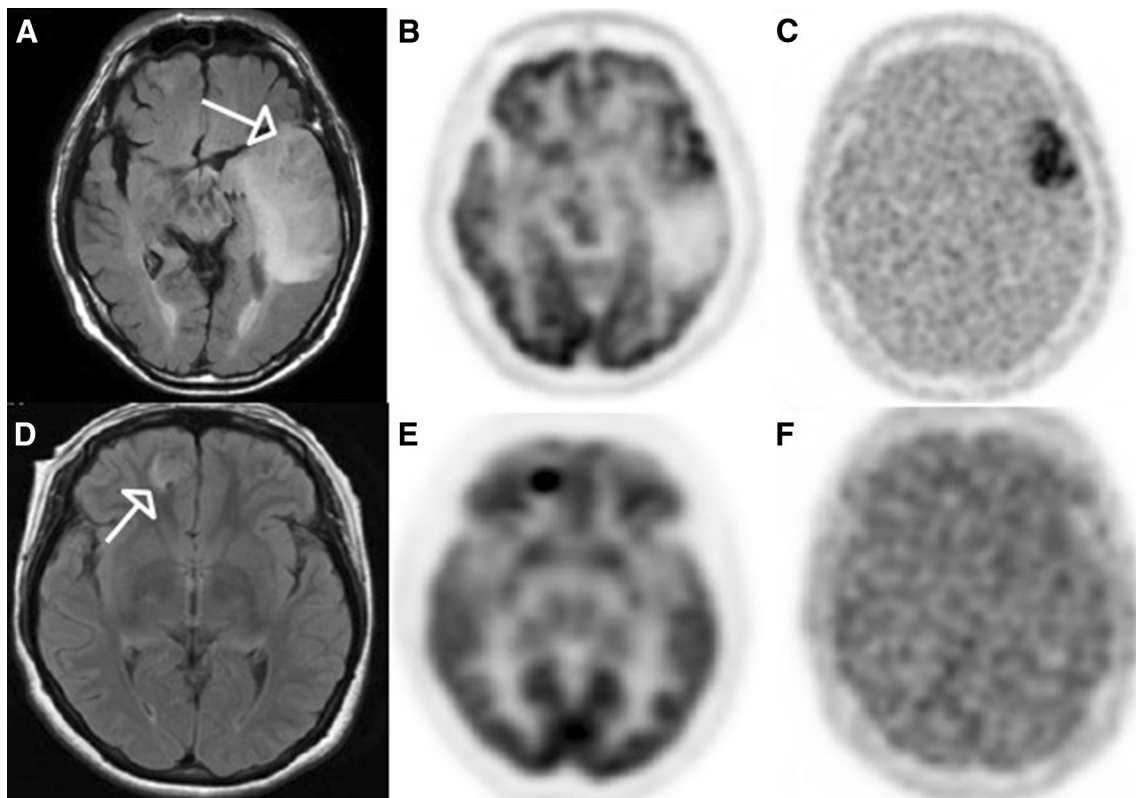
A representative case of glioblastoma (grade IV) localized at the left temporal lobe detected by fluid-attenuated inversion recovery MRI scan (a) with moderate FDG uptake (b) and increased FMISO uptake (c). Another example of a lesion in the right frontal lobe
